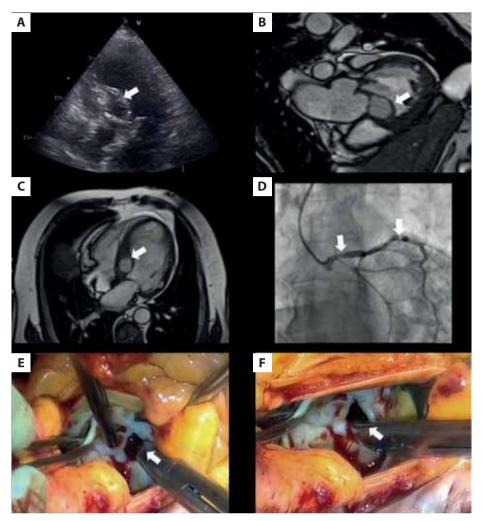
A. Transthoracic echocardiography — a cavity in the basal part of the interventricular septum (arrow). B. Cardiac magnetic resonance (CMR) — a cavity in the basal part of the interventricular septum (arrow). C. CMR — a cavity in the basal part of the interventricular septum (arrow). D. Coronary angiography — a caudal view of left main coronary artery stenosis on bifurcation with the left anterior descending artery and left circumflex coronary artery ostium (Medina 1-1-1) (arrow); subtotal stenosis of the left anterior descending artery on bifurcation with a large diagonal branch (Medina 1-1-1) (arrow). E. Intraoperative view of the intraventricular septum pseudoaneurysm cavity (arrow). F. Intraoperative view of the intraventricular septum pseudoaneurysm cavity (arrow)
